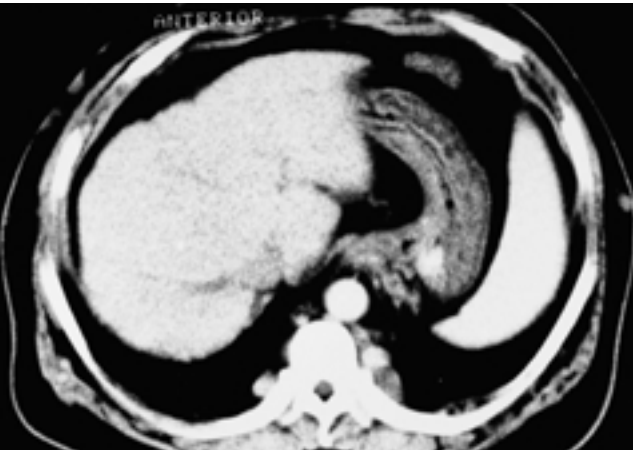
CT shows non-enhanced hepatic veins with underlying liver cirrhosis and multiple collateral vessels.
